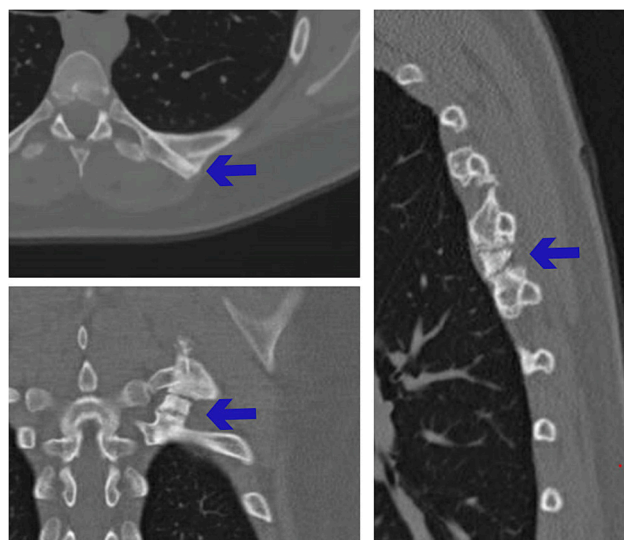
Pre-operative chest CT-scan with malunions of ribs 4 to 7 with heterotopic ossifications and bridging callus on the left side of the chest wall. Arrows represent an angulated malunion with protrusion into the erector spinae muscle in axial view (top left) and heterotopic ossifications between the ribs in axial and sagittal view (bottom left and right).
